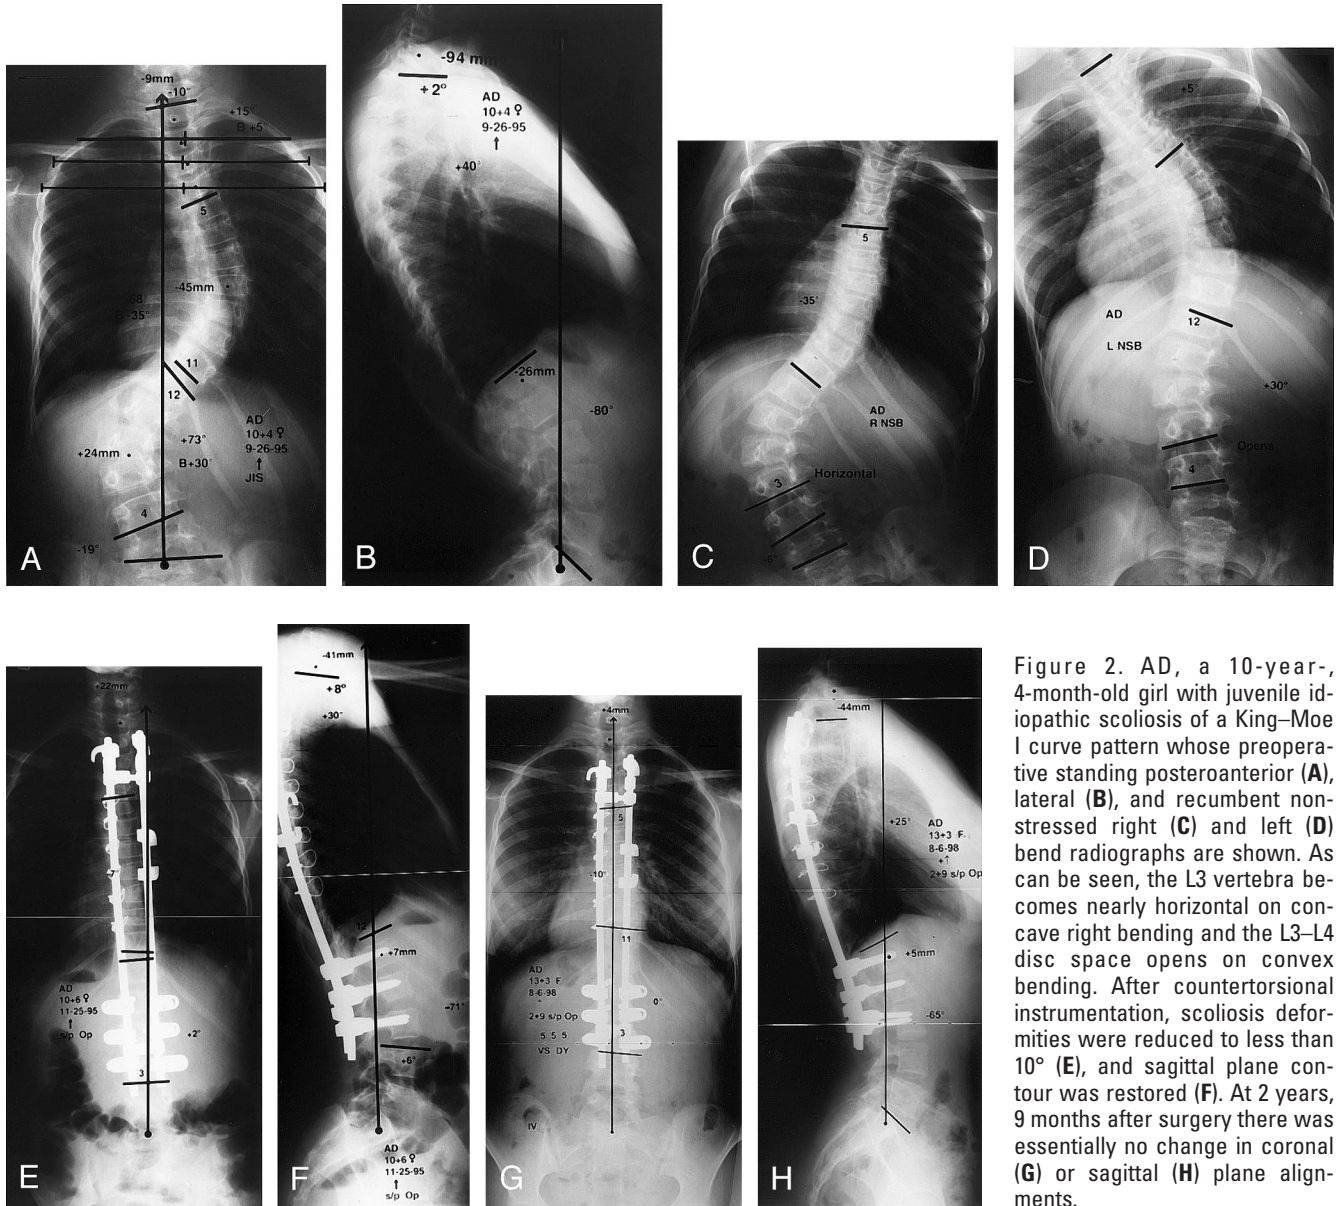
AD, a 10-year-, 4-month-old girl with juvenile idiopathic scoliosis of a King–Moe I curve pattern whose preoperative standing posteroanterior (A), lateral (B), and recumbent non-stressed right (C) and left (D) bend radiographs are shown. As can be seen, the L3 vertebra becomes nearly horizontal on concave right bending and the L3–L4 disc space opens on convex bending. After countertorsional instrumentation, scoliosis deformities were reduced to less than 10° (E), and sagittal plane contour was restored (F). At 2 years, 9 months after surgery there was essentially no change in coronal (G) or sagittal (H) plane alignments.
